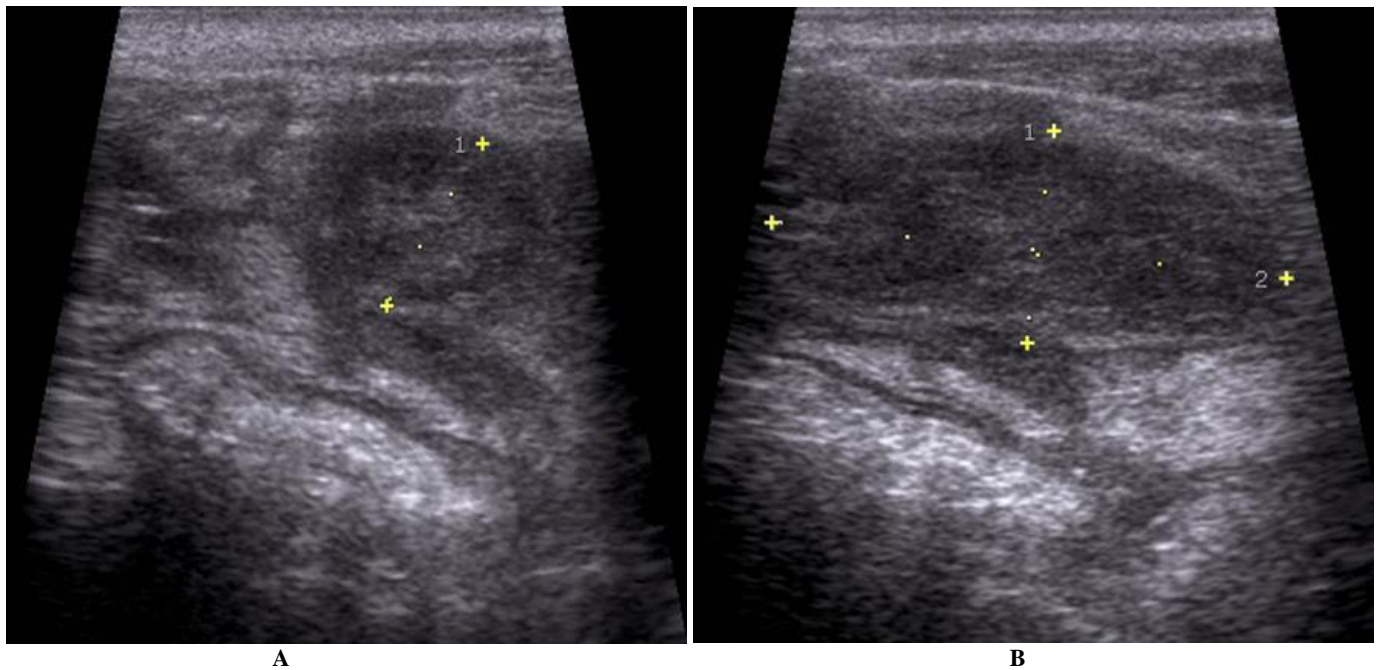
(A) ultrasound axial cut showing a thickness appendix hypoechoic and a fat infiltration around the appendix. (B) ultrasound longitudinal cut showing a thickness appendix hypoechoic
